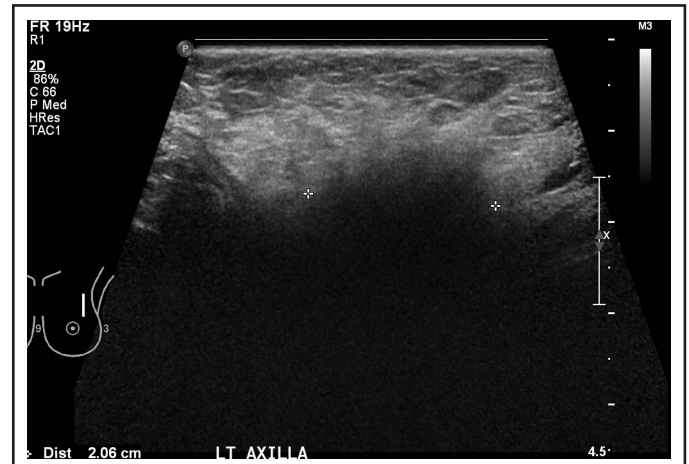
Ultrasound: L Breast. Using tissue harmonics to emphasize areas of shadowing.
